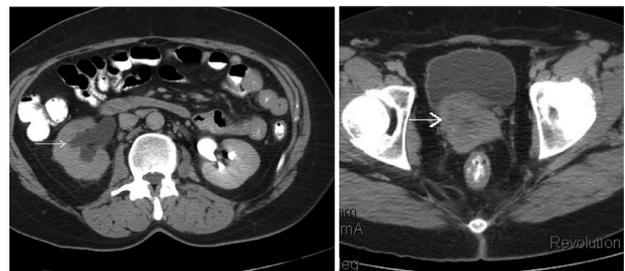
CT images reveal right hydronephrosis due to obstruction of the distal right ureter by a large cervical mass.
